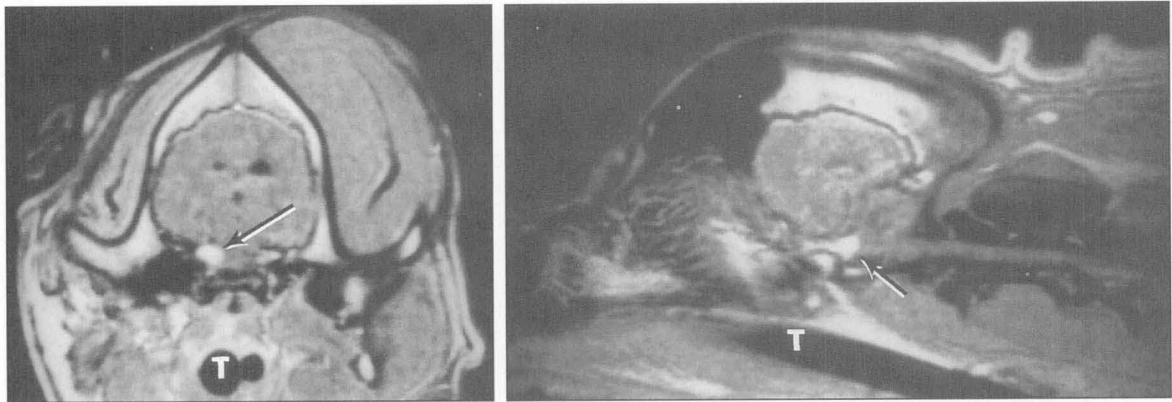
Transverse (left) and right parasagittal (right) T1-weighted magnetic resonance images made after administration of contrast medium. A well-defined intensely enhancing area (arrows) is evident in both views. Left—The mass is evident adjacent to the right petrous temporal bone. Notice the marked muscle atrophy and intensity of the right temporalis muscle, compared with the left muscle. Right—The mass is adjacent to the right ventrolateral portion of the calvarium. T = trachea.
